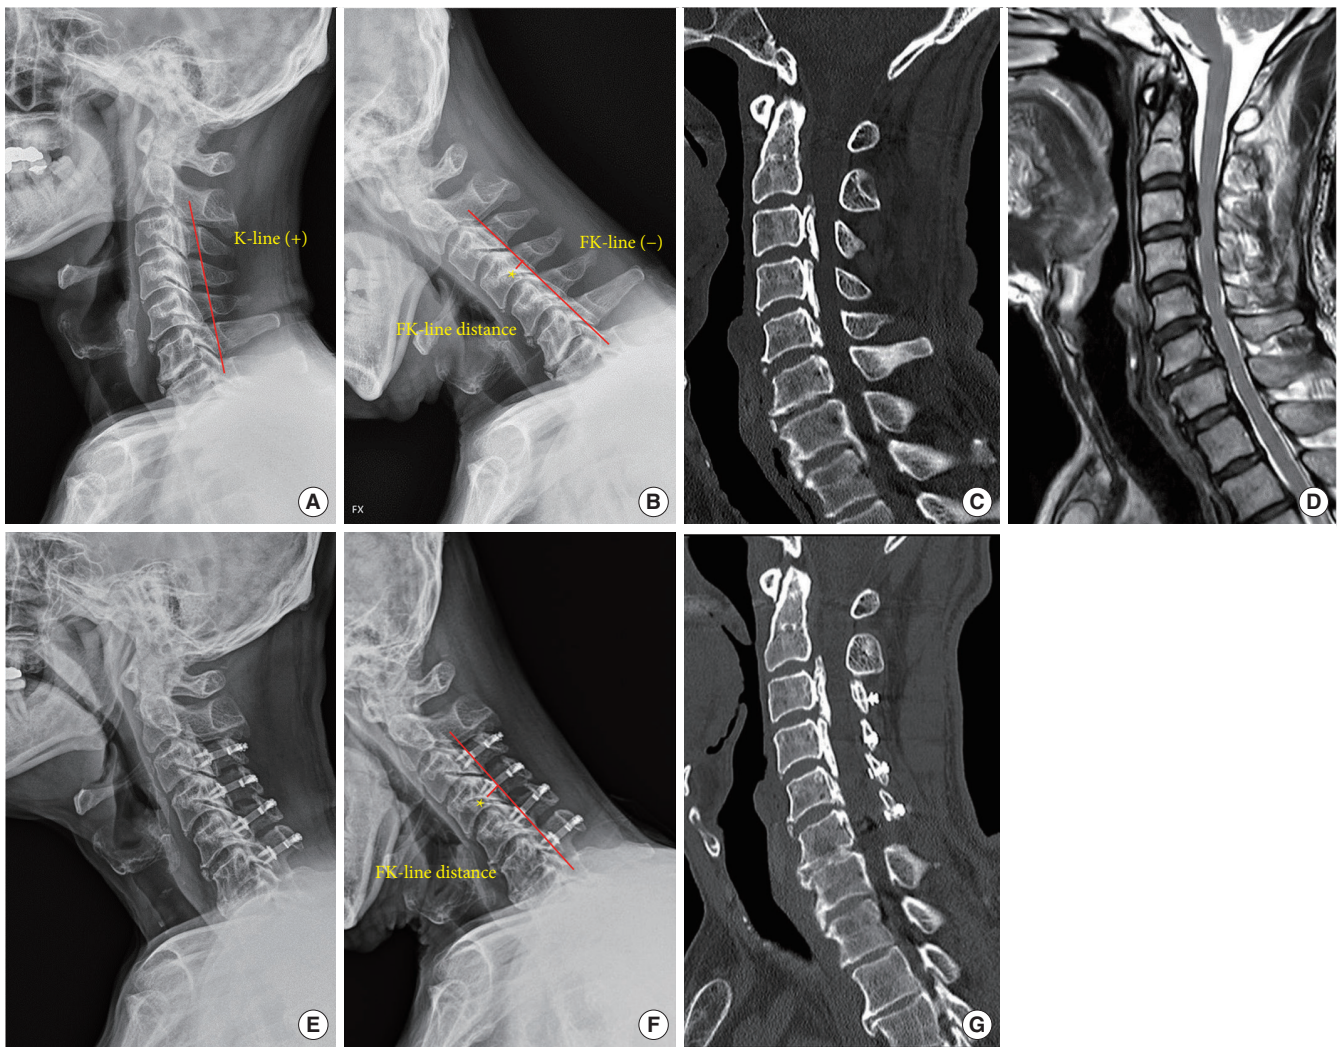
Representative case of LP in a patient with FK-line (-). A 59-year-old man with cervical OPLL involving C3–T1 presented with bilateral numbness, weakness, and gait ataxia. (A) Preoperative radiograph showed lordotic alignment and a positive K-line. (B) Flexion radiograph revealed a negative K-line (FK-line [-]) with an FK-line distance of 4.7 mm (asterisk). (C) Sagittal computed tomography (CT) showed mixed-type OPLL from C3 to T1. (D) T2-weighted magnetic resonance imaging demonstrated significant spinal cord compression. (E) Postoperative radiograph after LP at C3–6 showed loss of cervical lordosis. (F) Postoperative flexion radiograph showed a kyphotic C2–7 angle and an FK-line distance of 5.0 mm (asterisk). (G) Postoperative CT scan confirmed widening of the spinal canal. The JOA score improved from 12 to 13 (recovery rate: 20%) at 2-year follow-up. LP, laminoplasty; FK-line, flexion K-line; OPLL, ossification of the posterior longitudinal ligament; JOA, Japanese Orthopaedic Association.
